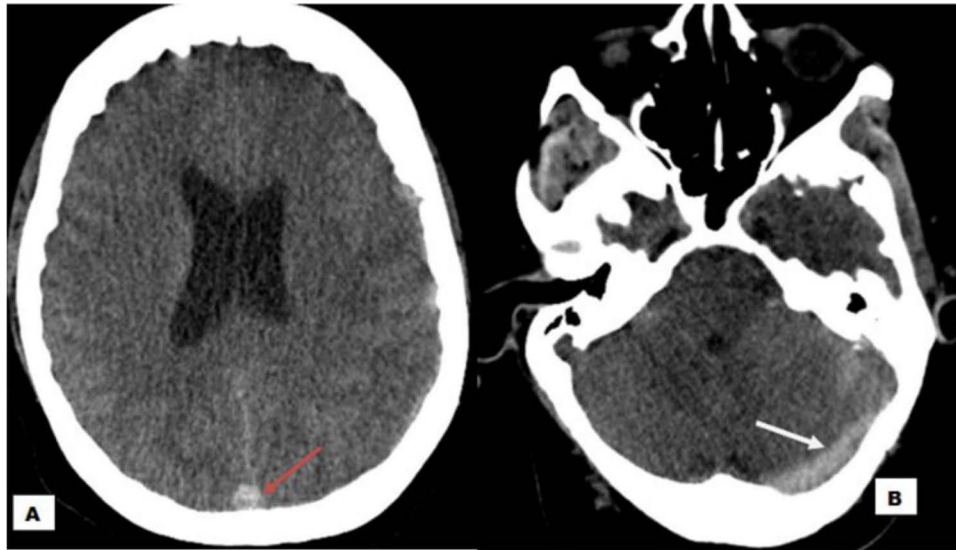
Non-contrast computed tomography of the brain revealed a hyperdense superior sagittal sinus (A) and left transverse sinus (B) both the red and white arrow indicating dural sinus thrombosis.
